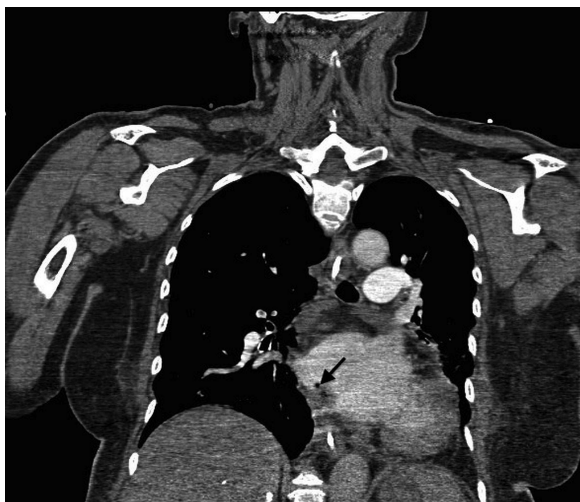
Coronal thoracic CT images demonstrating air in the left atrium (see arrow).
